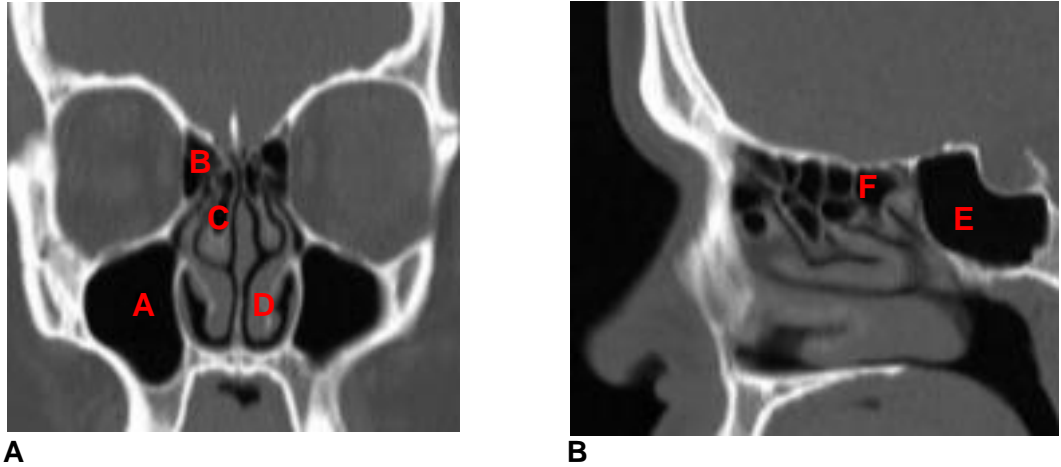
CT scan images with coronal (A) and sagittal (B) views of the sinuses.
